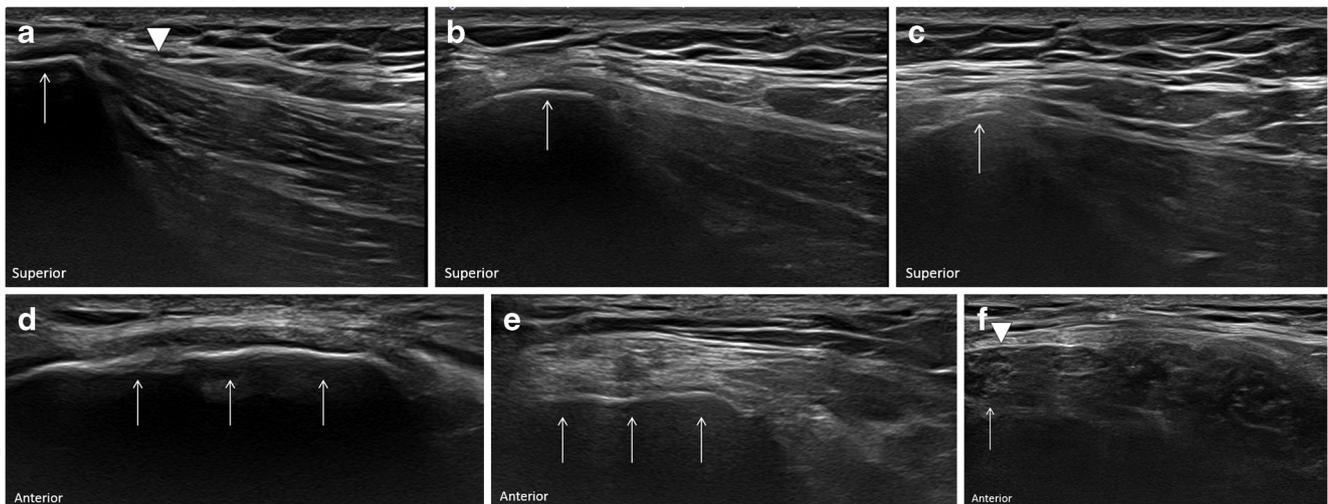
A 33-year-old asymptomatic male volunteer. a–c High-resolution ultrasound (24-MHz transducer) demonstrates normal anatomy of the FLAIC in the longitudinal plane. *Left* of image is superior or cranial orientation relative to the patient. a, b The tensor fascia lata attaches along the anterior outer lip of the iliac crest (*arrow*) with the superficial layer of the iliotibial band (*arrowhead*) seen coursing superficial to the tensor fascia lata and attaching at the iliac crest. b Slightly more posteriorly, the superficial layer of the iliotibial band demonstrates a thick attachment at the iliac tubercle (*arrow*). c Further posteriorly, the gluteal aponeurotic
